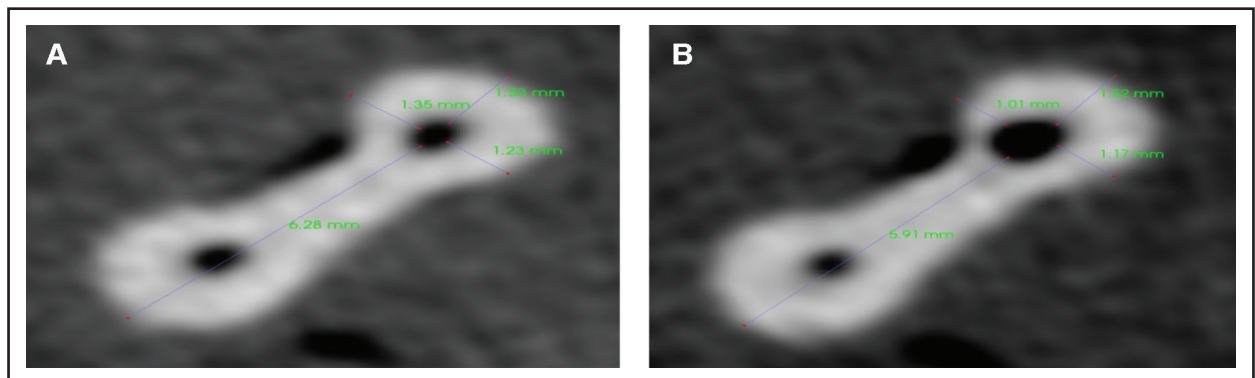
CBCT , A) pre- and B) post-instrumentation images of a sample prepared with Neoniti CM at 6-mm distance from the apex.
